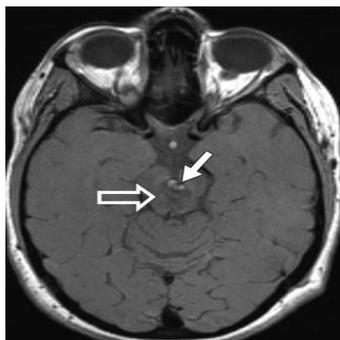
Axial MRI T1 weighted image
